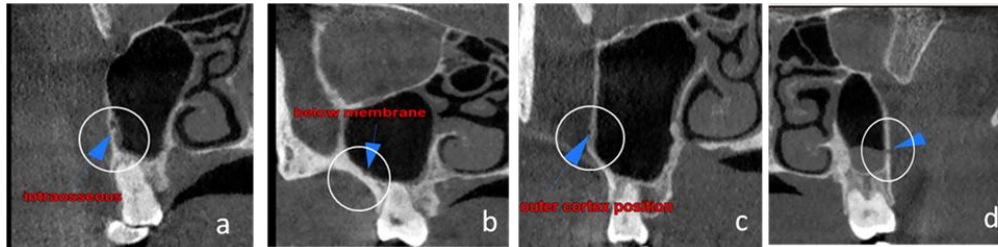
Coronal CBCT images showing PSSA canal on lateral walls of maxillary sinus; (a) intraosseous, (b) intrasinusal, (c) superficial, (d) transosseous
